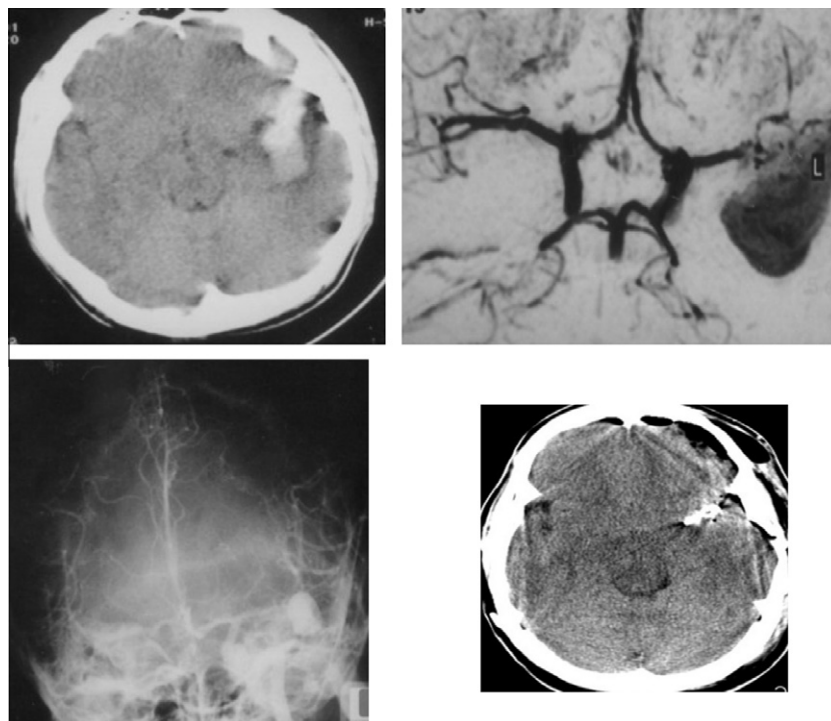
CT scan (axial view) showing spontaneous left sylvian ICH in male child aged 17 years. CT angiography showing the left sylvian ICH without evidence of an aneurysm. Conventional angiography showing left middle cerebral artery aneurysm. Post-operative CT scan (axial view) showing clipping of the left middle cerebral artery aneurysm.
